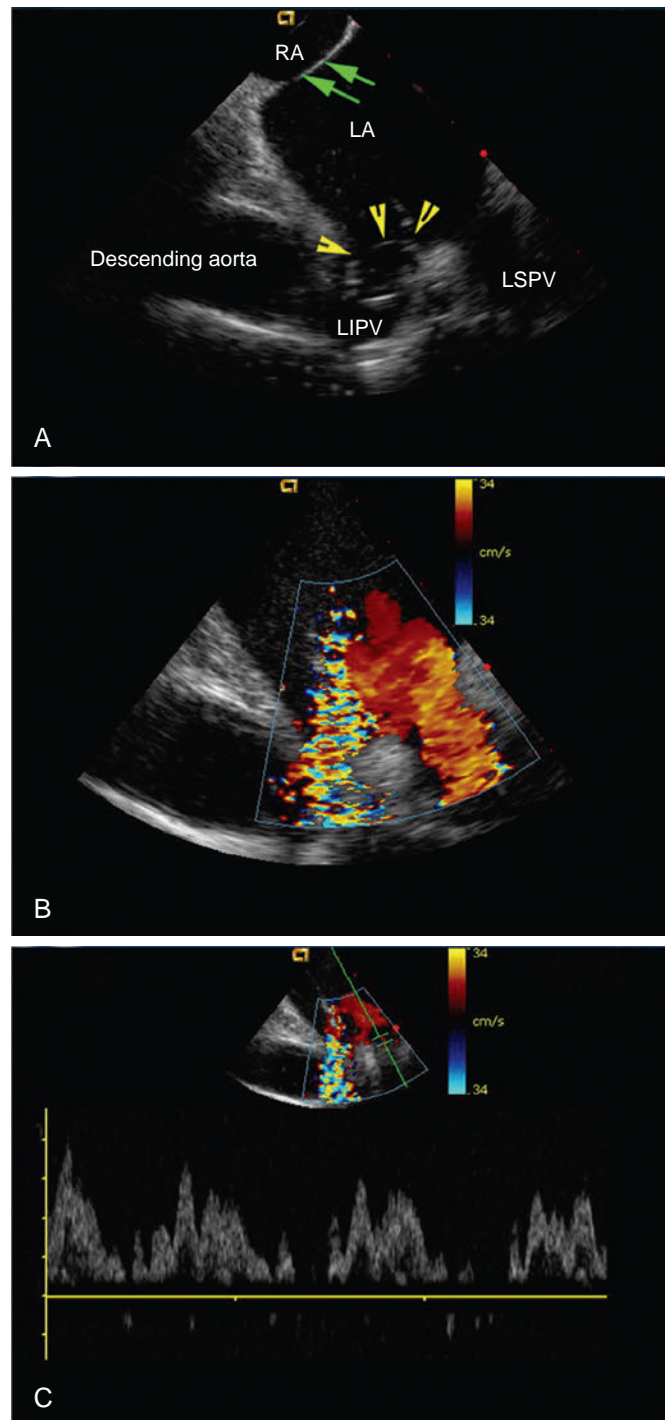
Intracardiac Echocardiographic (ICE) Images of the Left Pulmonary Veins With Transducer Placed in the Right Atrium (RA). (A) The RA, interatrial septum (green arrows), left inferior pulmonary vein (LIPV), left superior pulmonary vein (LSPV), and descending aorta are visualized. The Lasso catheter (yellow arrowheads) is visualized at the ostium of the LIPV. Color Doppler images of both LIPV and LSPV (B) and a pulsed-wave Doppler tracing (C) obtained from the LSPV are shown. LA, Left atrium.
